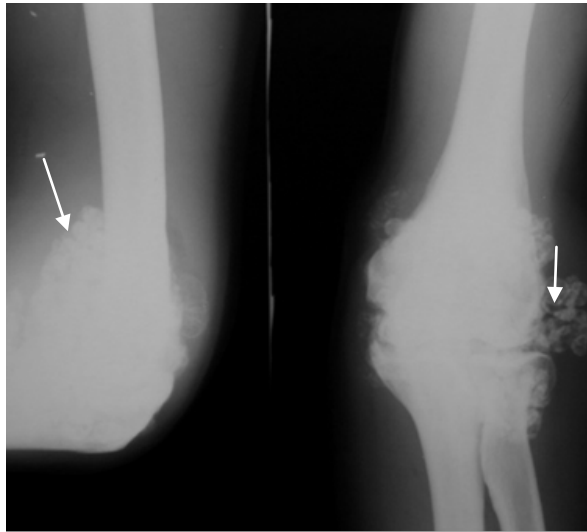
The radiograph of the ulnar joint in direct and lateral projections. The pathological mass, which surrounds the ulnar joint (arrows) is detected. There are lucent sites and zones of calcifications with various sizes and forms; contours are distinct, but not along the whole length. Ecchondroma of ulnar joint bones
